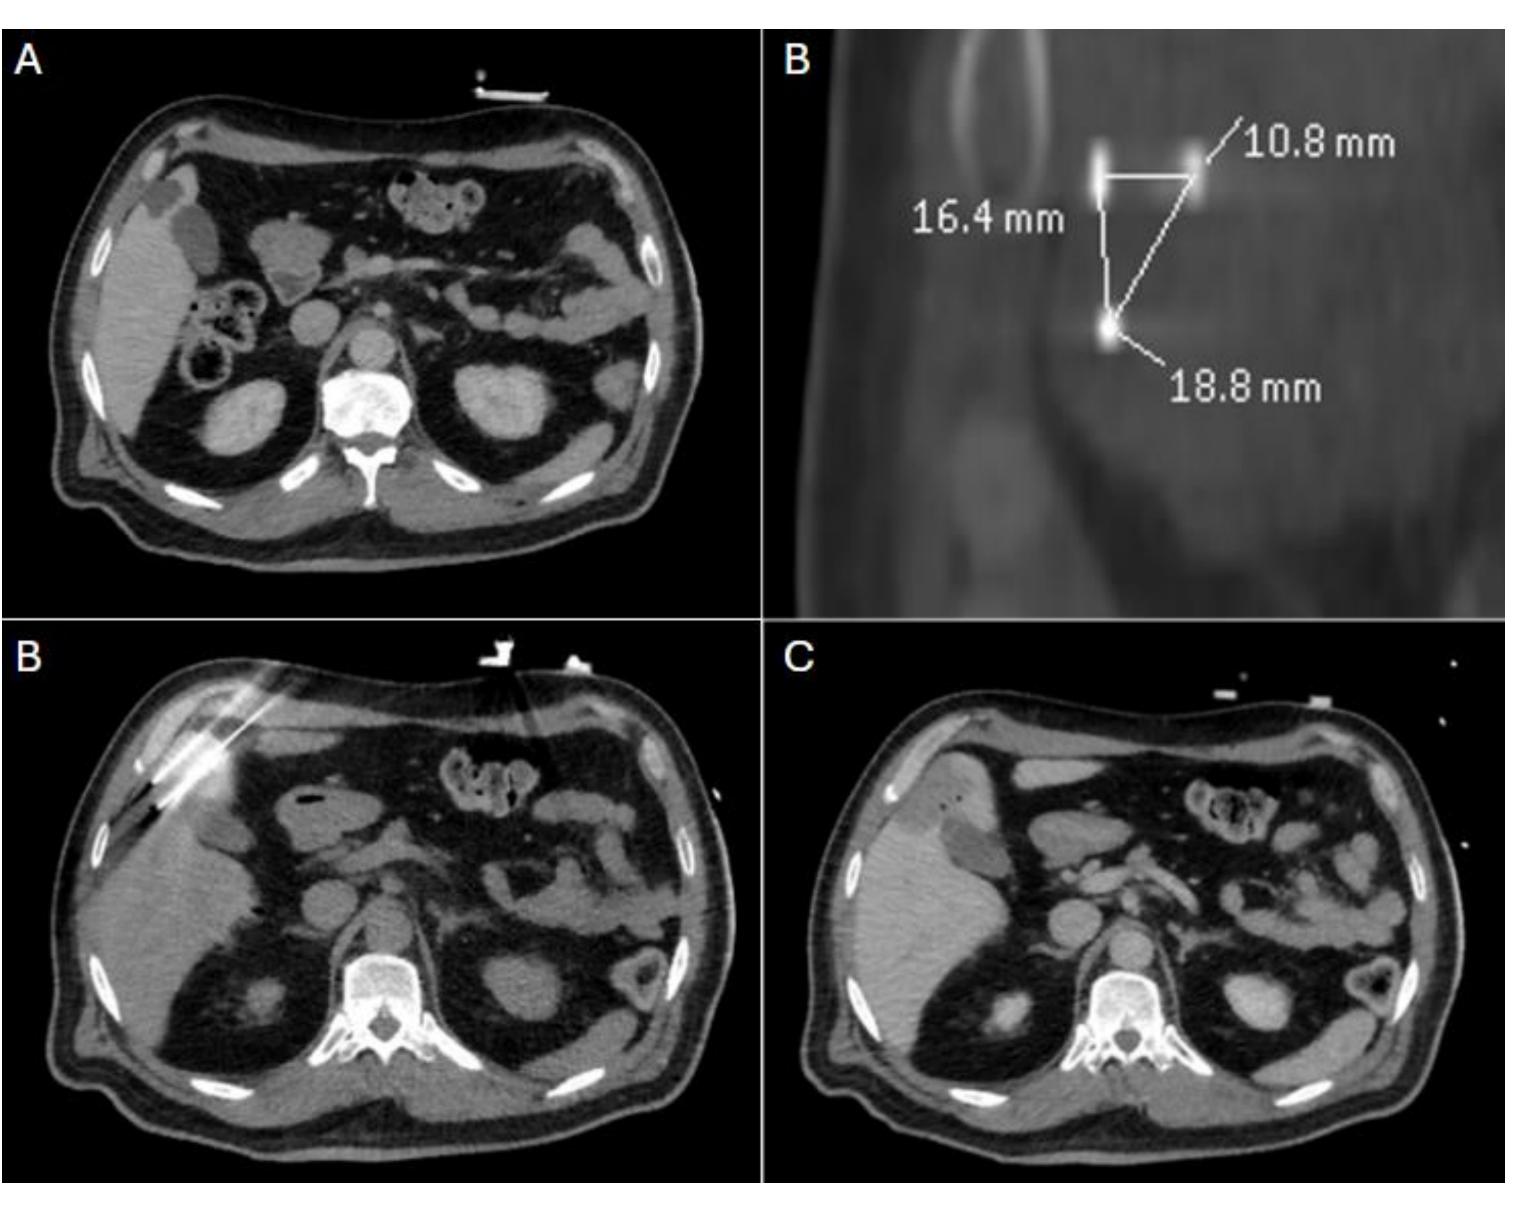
(A) Preprocedural CT demonstrates the 2.5 cm segment 4b cystic lesion. (B) Intraprocedural CT demonstrating intermittent placement of three 19-gauge IRE ablation needles. (C) Post-procedural CT demonstrates adequate coverage of the ablated lesion in 4b with peripheral hyperemia.
